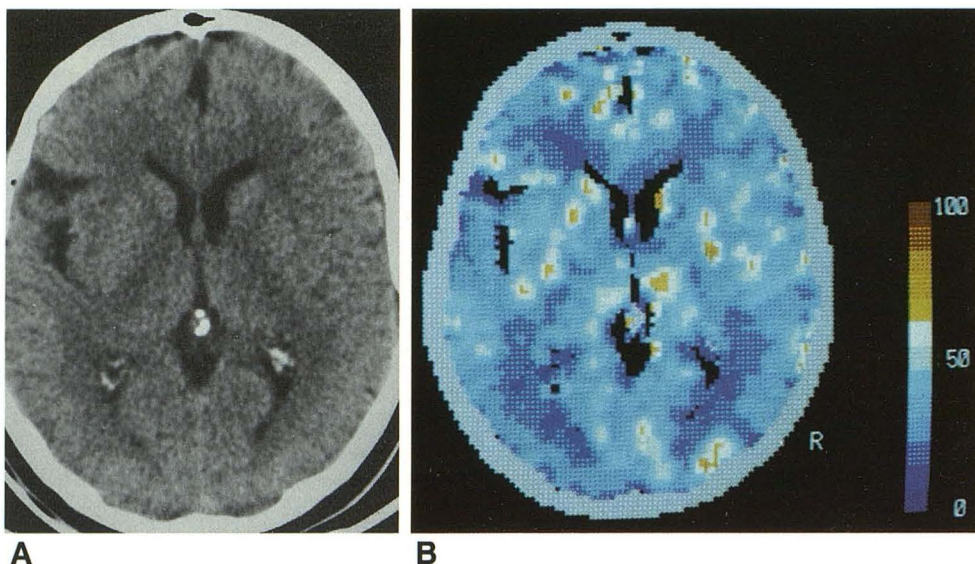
Noncontrast CT image of the brain (A) and corresponding local cerebral blood flow (B) in a 65-year-old man with multi-infarct dementia. Minimal high-intensity signals were seen on MR but no periventricular lucencies were seen on CT. Values for local cerebral blood flow of white matter (17.6 ml/100 g brain/min), as well as cortical (37.1) and subcortical (50.4) gray matter, are decreased, but not to the same degree as shown for the more severely affected patient in Fig. 2. On both images, left hemisphere is to the left and right hemisphere is to the right.
